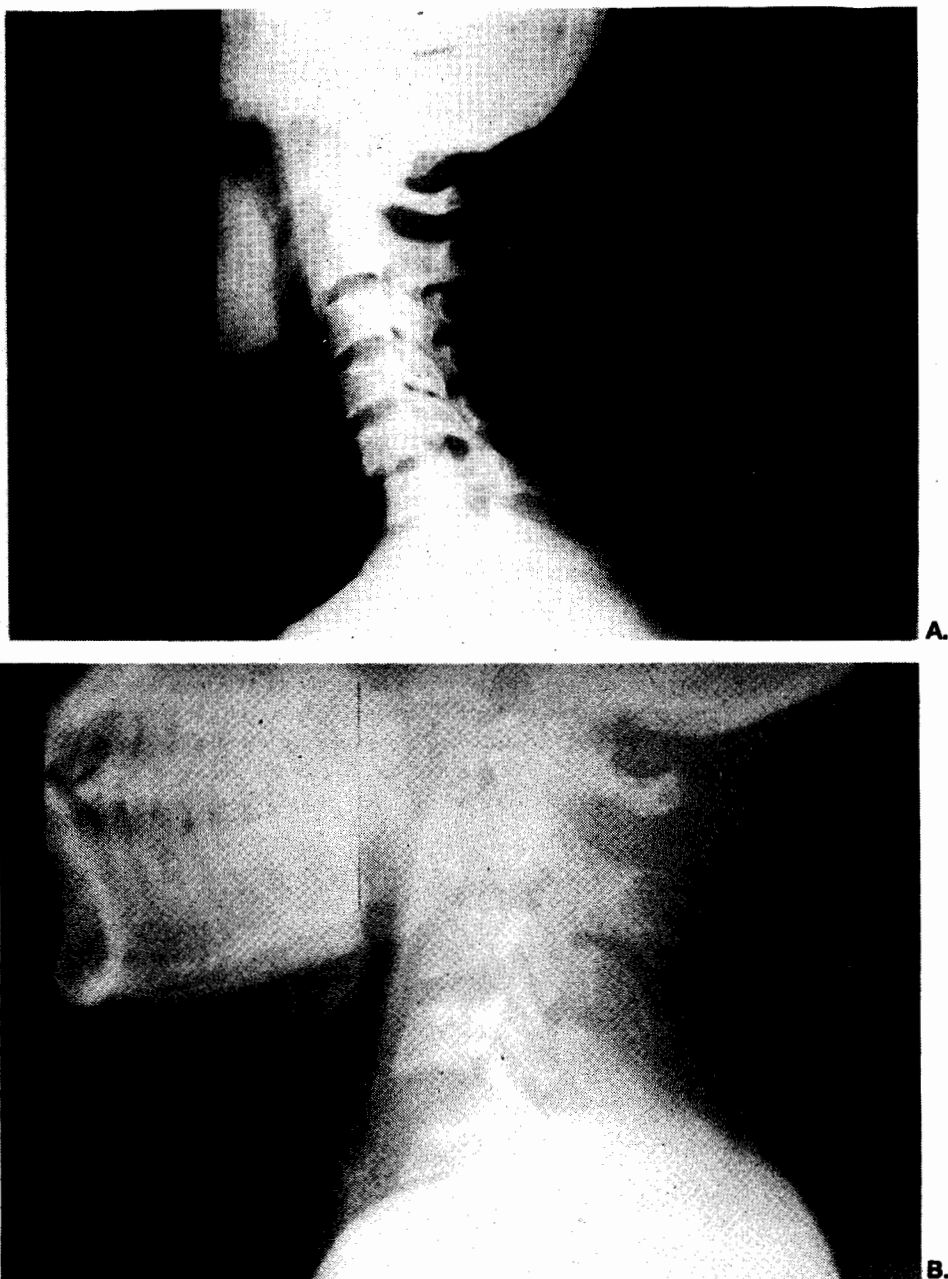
(A) Lateral radiograph of unilateral facet dislocation cause minimal anterior displacement of C5 on C6. Also note fracture spinous process of C6.
